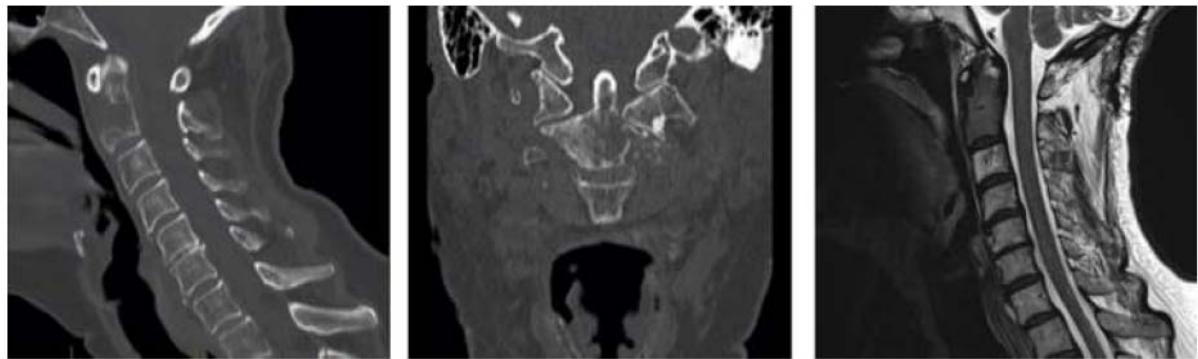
Left: Pre-operative CT, sagittal. Almost complete erosion of the body of C2. Middle: Preoperative CT, coronal, demonstrating the extent of the bony erosion including the vertebral body and left articular pillar Right: pre-op diagnostic MRI demonstrating metastasis in C2
